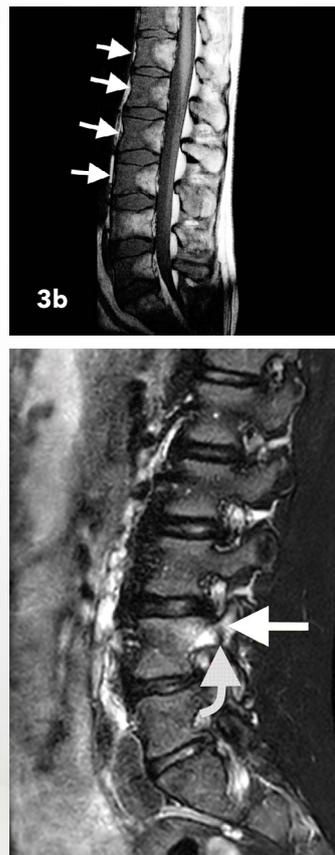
Sagittal STIR MR image showing a pedicular fracture as a low signal intensity line (curved arrow) with adjacent vertebral oedema that extends into the superior articular process (straight arrow).
